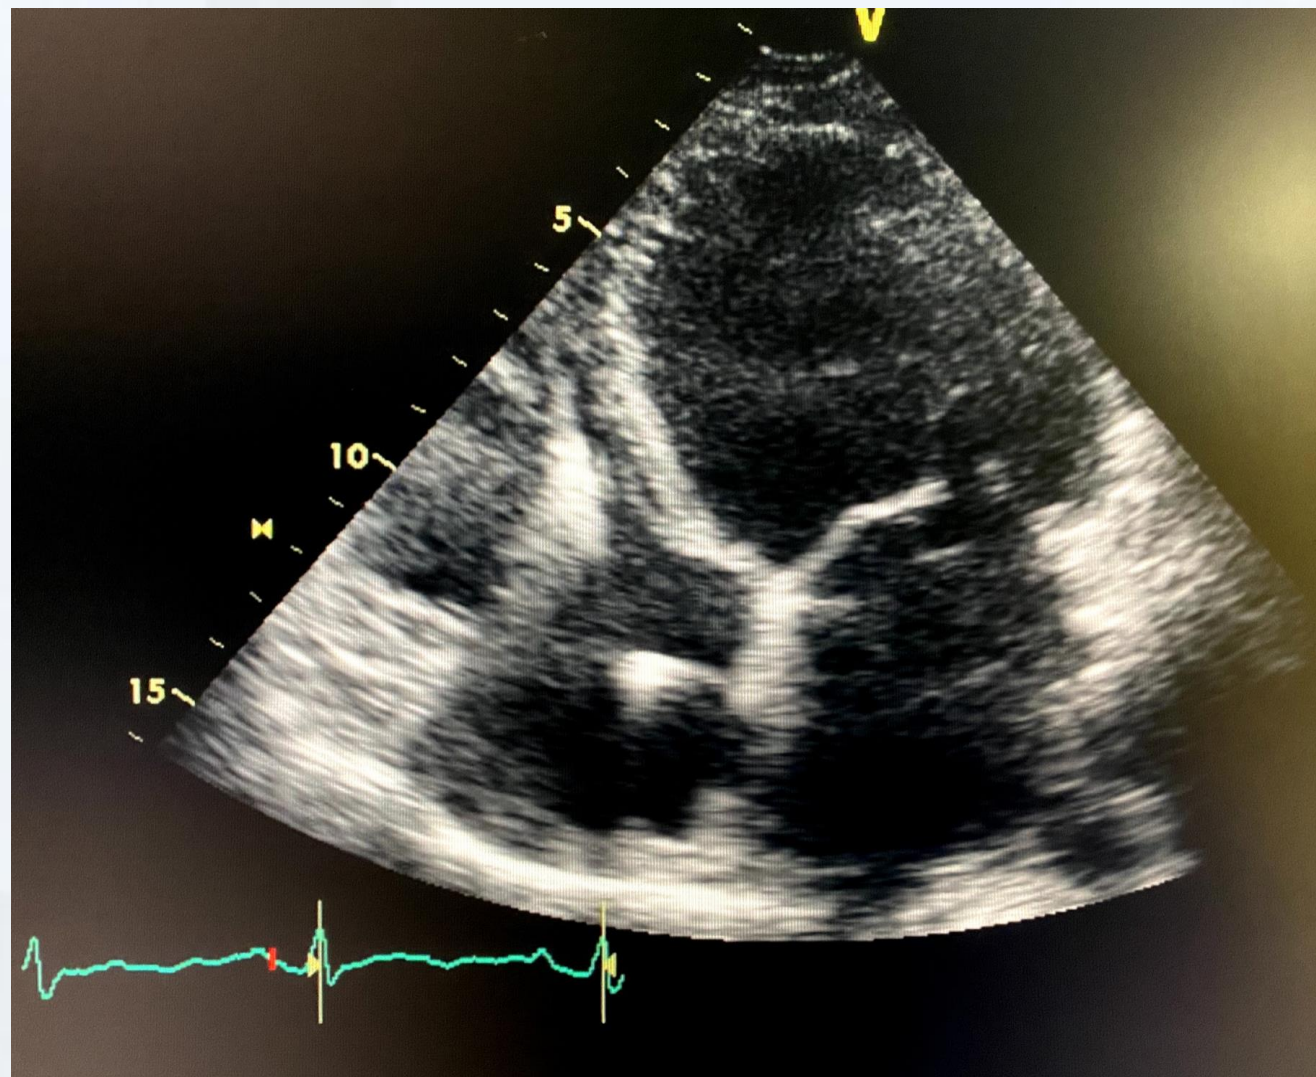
Echocardiogram during diastole.
